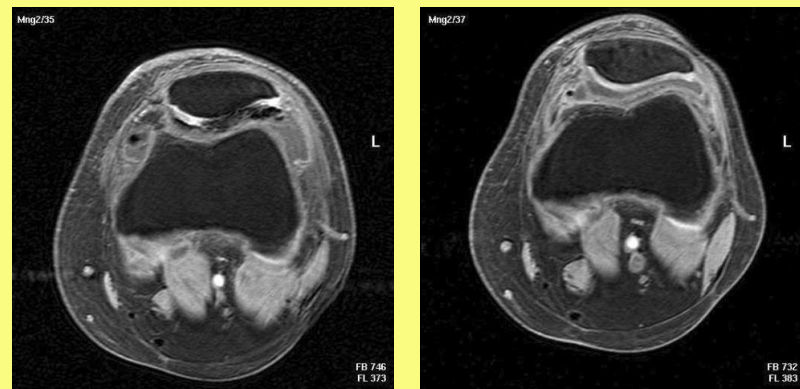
MRI 4 days (left) and 4 months after reconstruction with stabilized fibrin-chondrocyte-collagen constructs
